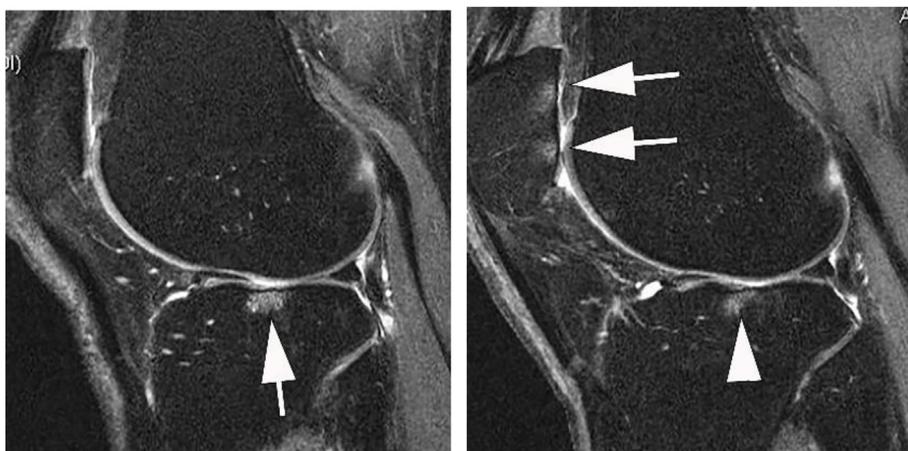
Scoring of within-grade changes of structural features of OA (applied particularly to cartilage and BMLs) has shown validity and may be clinically relevant. A. Baseline sagittal intermediate weighted fat-suppressed MRI shows a grade 1 BML at the central subregion of the lateral tibia (arrow). B. At 1 year follow-up the BML is still present but has visually decreased in size (arrowhead). This will be scored as a within-grade change over time (i.e. definite visual change not fulfilling a full grade change on the MOAKS scale). In addition, there are two new BMLs at the lateral patella (arrows).
